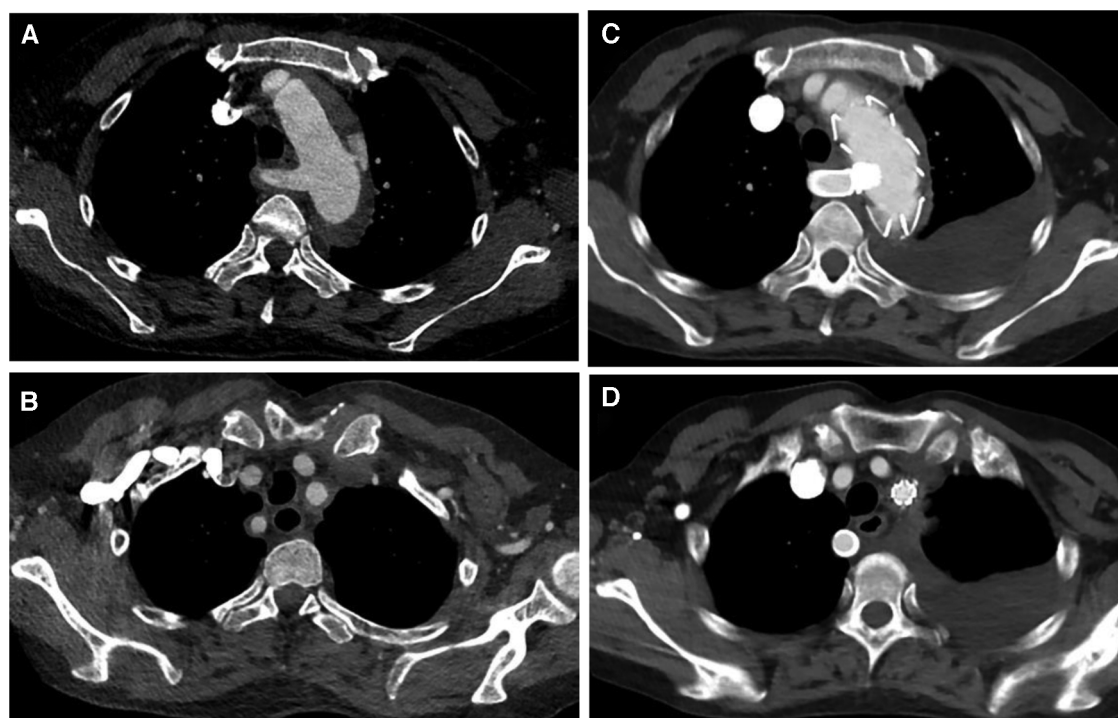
(A,B) Preoperative CT angiography of patient 4, who underwent castor stent graft and fenestration; (C,D) postoperative CT angiography, blood flow was fluent in LSA and ARSA.
